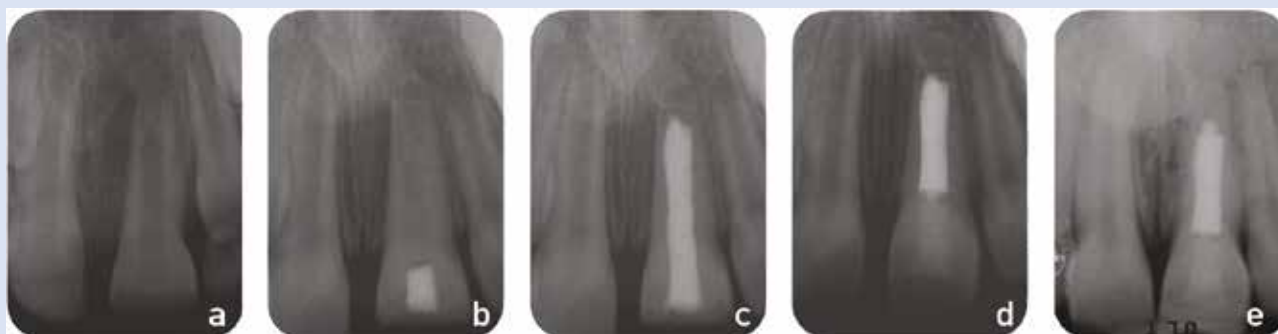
A: Preoperative X-ray of necrotic immature tooth 2.1 in a 8 y/o patient. A dental trauma was reported 6 months before and the tooth was not restored.
